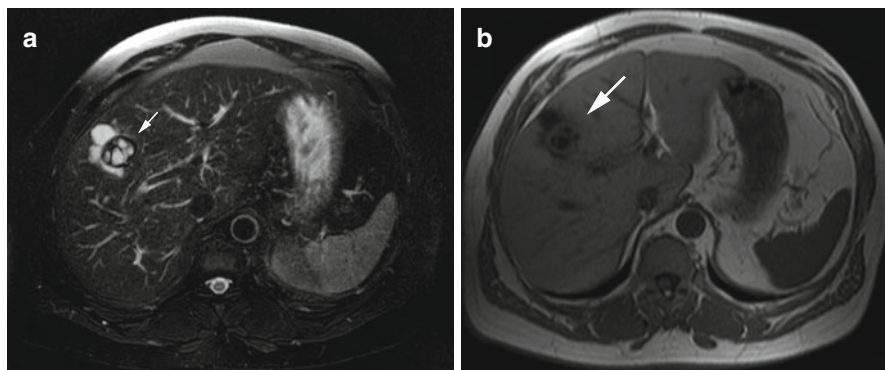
A 50-year-old Mediterranean man with an echinococcal cyst of the liver suggested by MRI appearance (*arrow*) and confirmed by serology. Fat-saturated T2w TSE image (a) and 2D T1w FLASH image (b) show a septated cystic mass with sharp margins in segment VIII
